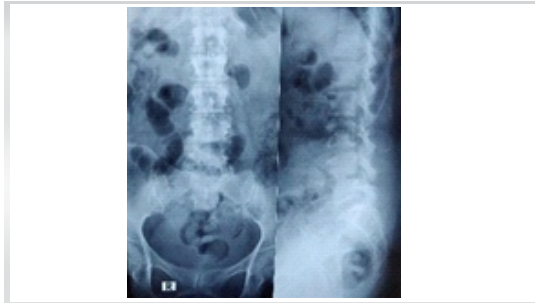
X-ray L-S spine A/P & lateral view showing L4-5 spondylodiscitis
